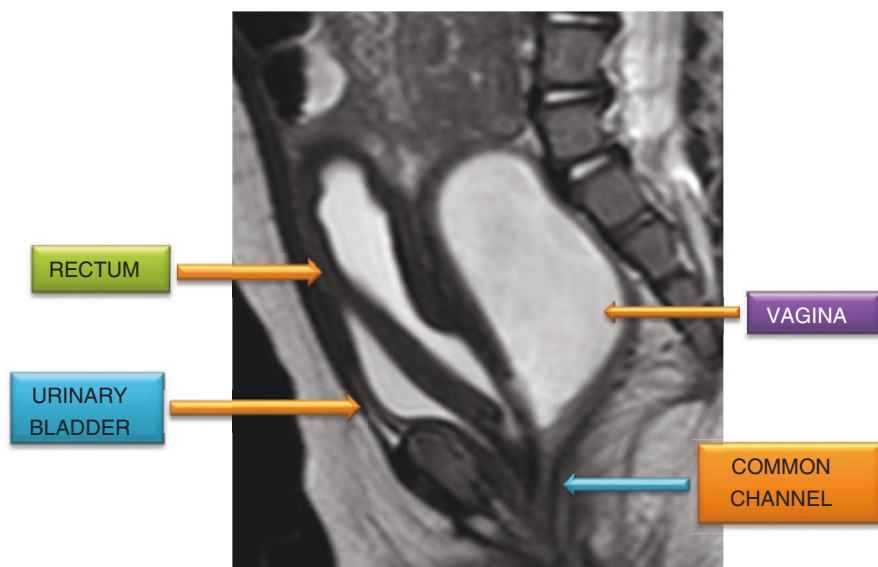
MRI of a patient with cloaca showing the rectum, urethra and vagina joining distally together in a common channel. Note the abnormal position of the vagina which is located posteriorly and the rectum anteriorly
